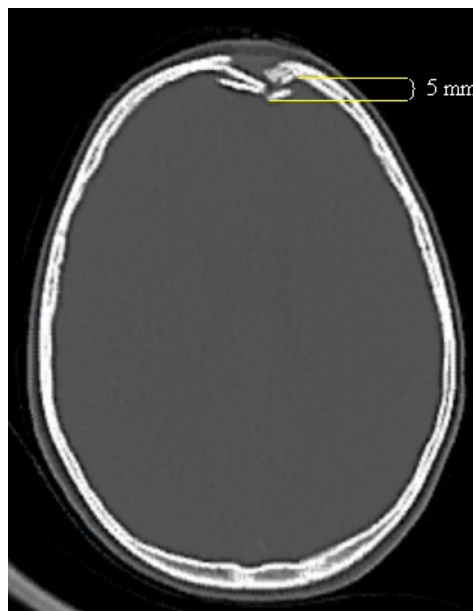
Non-contrast CT of the head showing measuring depth of depression of the fracture.
